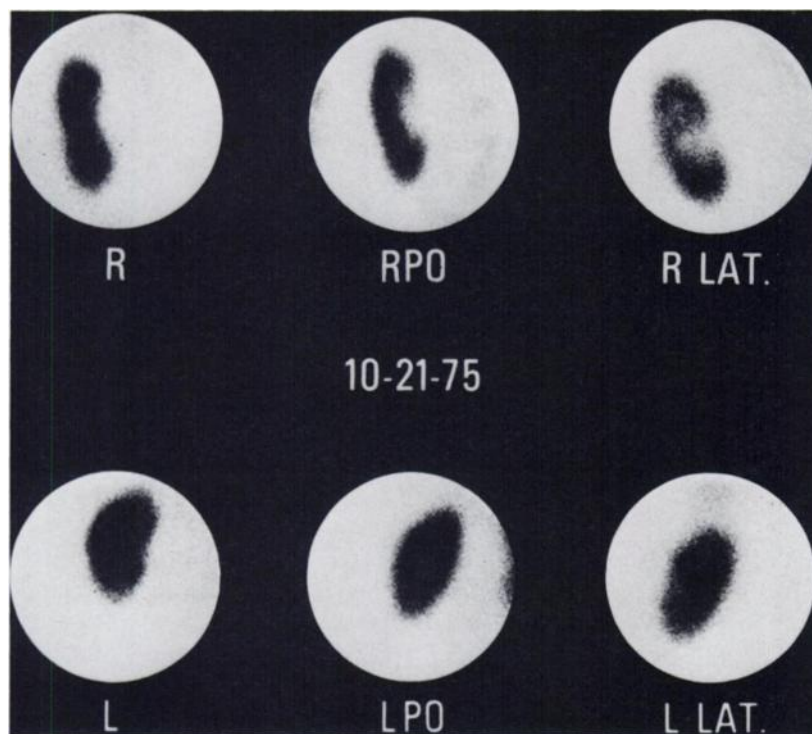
Right renal cyst proven by ultrasound and cyst puncture. Liver uptake is essentially absent.
